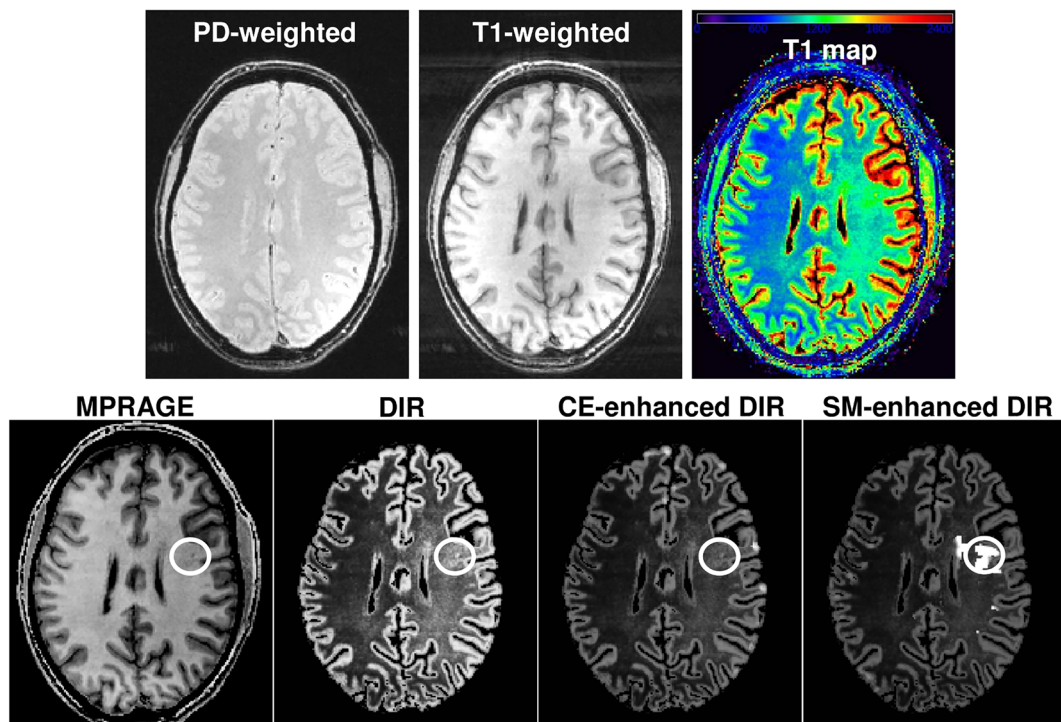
False positive caused by subject movement (healthy subject). Top row, from left to right: PD- and T1-weighted image, and resulting T1 map. Bottom row, from left to right: MPRAGE, DIR, CE- and SM-enhanced DIR. The T1-weighted image shows a movement artifact (horizontal stripes in background, signal reduction in right hemisphere), yielding increased T1 values in the right hemisphere and a hyperintensity in the SM-enhanced DIR image, erroneously suggesting an FCD at the site marked with a circle
